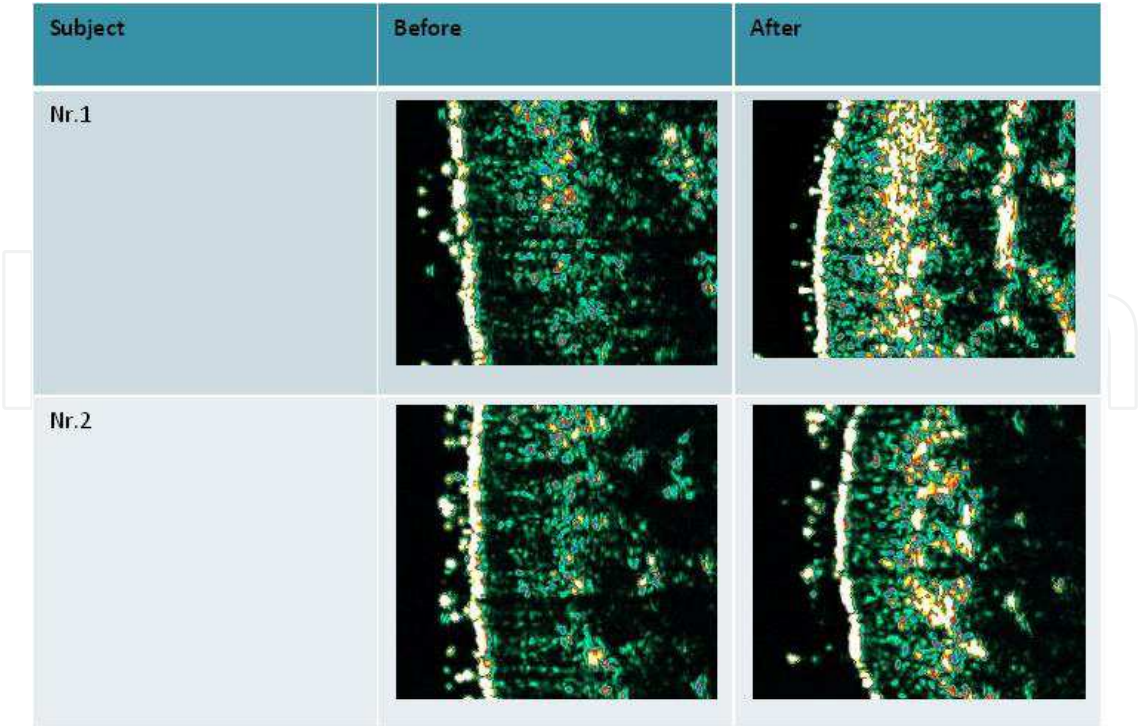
Ultrasonographic evaluation of the zygomatic area, before and after topical P63 therapy
